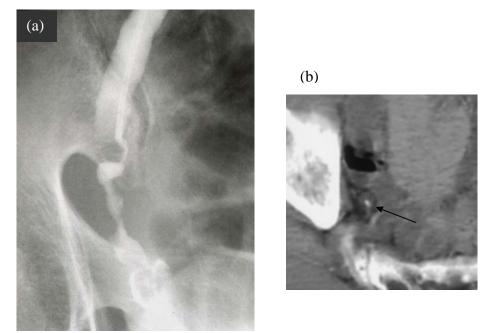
Retrograde ureterography (a) and CT (b) imaging of locally advanced invasive ureteral cancer. Retrograde ureterography shows irregular stenosis of ureter and CT imaging shows irregular thickness of ureteral wall (arrow).
